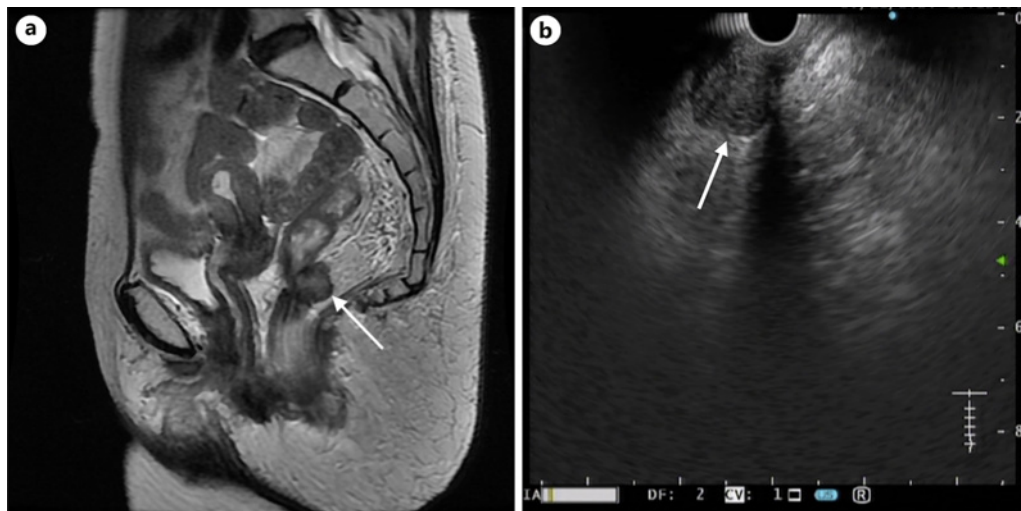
a, b MRI and EUS-FNA images of the remnant perirectal lesion.
